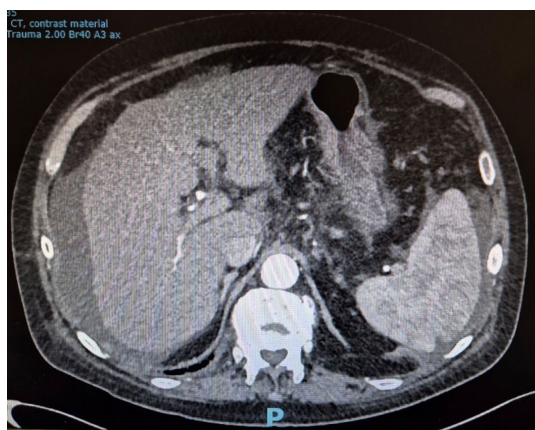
Contrast-enhanced abdominal CT demonstrating large-volume of abdominal free fluid, cirrhotic liver morphology.
